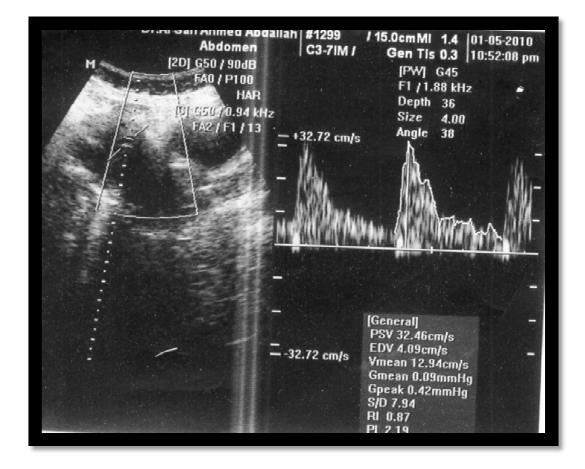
32 years old women with a history of (RPL) color Doppler scan shows complete abortion.
